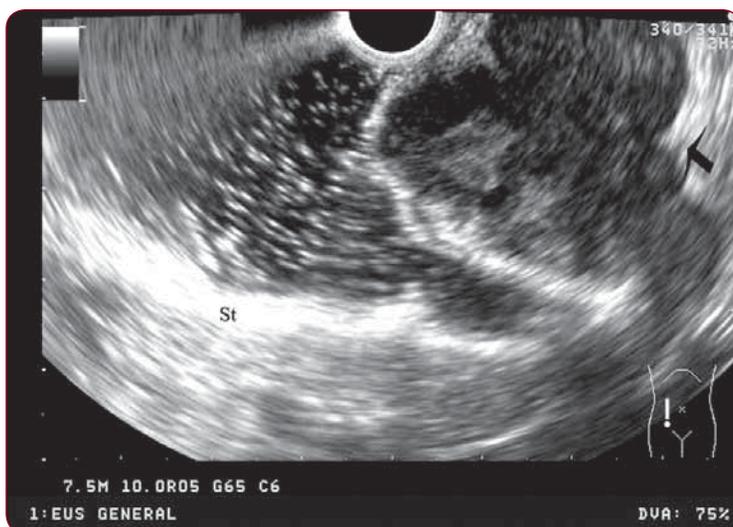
Endoscopic ultrasound image of submucosal, polilobated tumour (black arrow)
